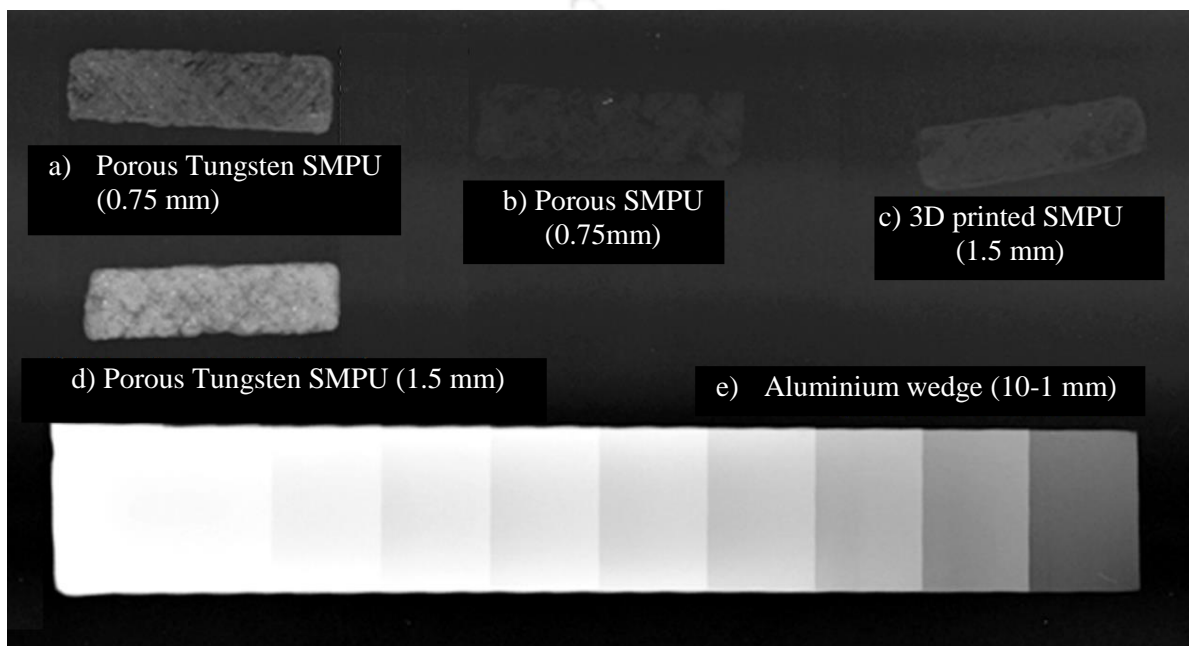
X-ray image of the 3D printed samples: (a) Porous Tungsten SMPU (0.75 mm), (b) porous SMPU (0.75mm), (c) 3D printed SMPU (1.5mm), (d) Porous Tungsten SMPU (1.5mm), (e) Aluminum wedge
